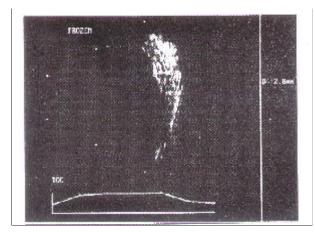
Ultrasonography of right eye showing marked choroidal thickening (2.8 mm) with retinal elevation.
